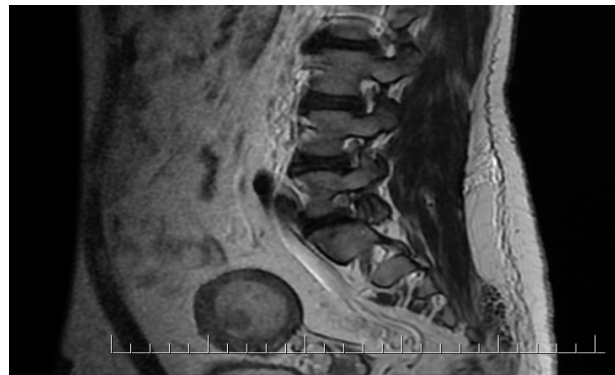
Ovarian mass as incidental findings in lumbosacral MRI in a patient with hip pain.
